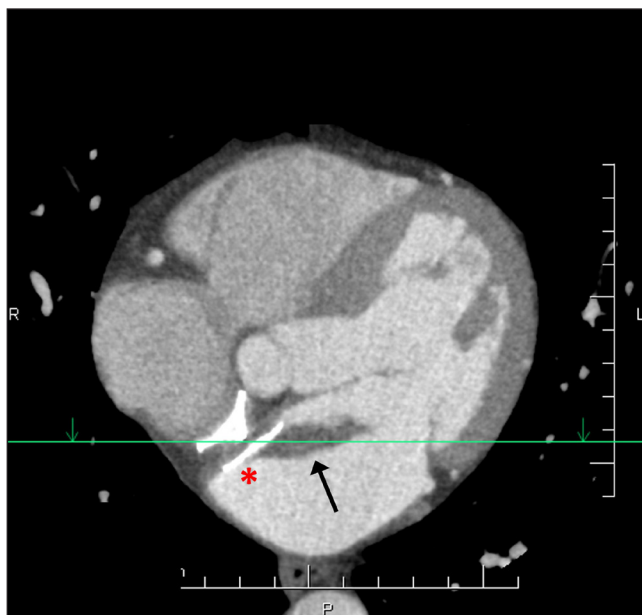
CT scan showing a mass (→) on the left atrial disk (\*) of the PFO occluder.
